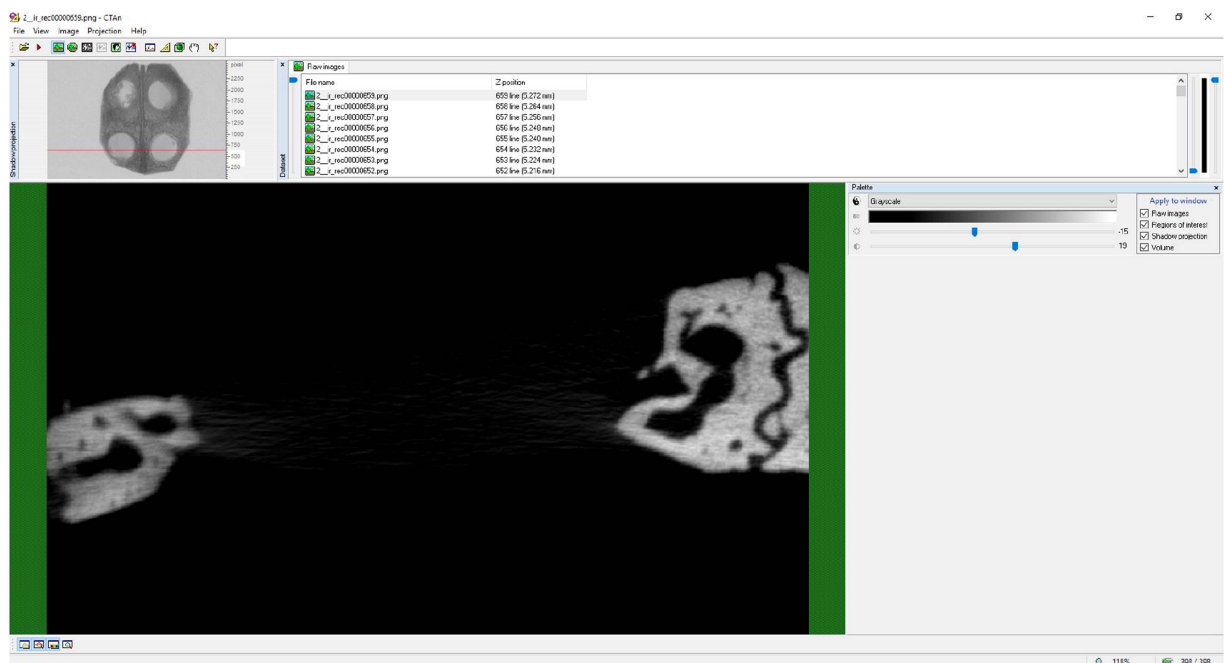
Software analysis interface. (A) CT vox 3D reconstruction. (B) CT Analyser for bone Bone Volume percentage analysis.
